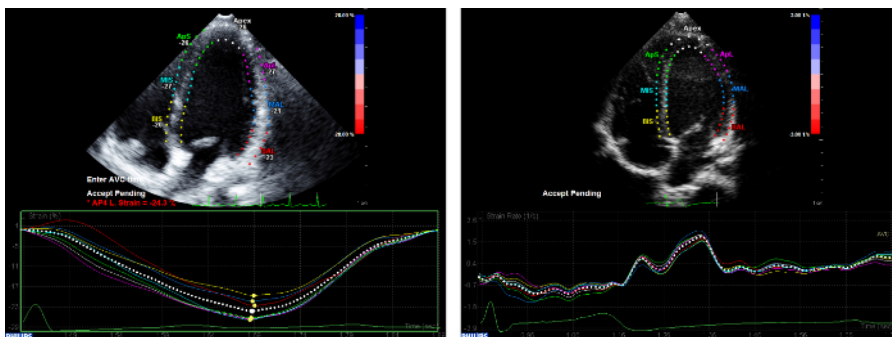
Apical 4-chamber view-derived longitudinal strain and strain rate. Apical 4-chamber view (AP4) derived ϵ and SR are presented in the left and right panels, respectively. Each colored time-strain curve (left and right, bottom) corresponds to one of the seven color-coded myocardial segments (left and right, top) and visualizes segmental (= regional) ϵ or SR, respectively. The white dotted line represents global longitudinal LV ϵ or SR, respectively. Note the smooth parallel shape of the segmental time-strain and SR curves. [Please click here to view a larger version of this figure.](#)
